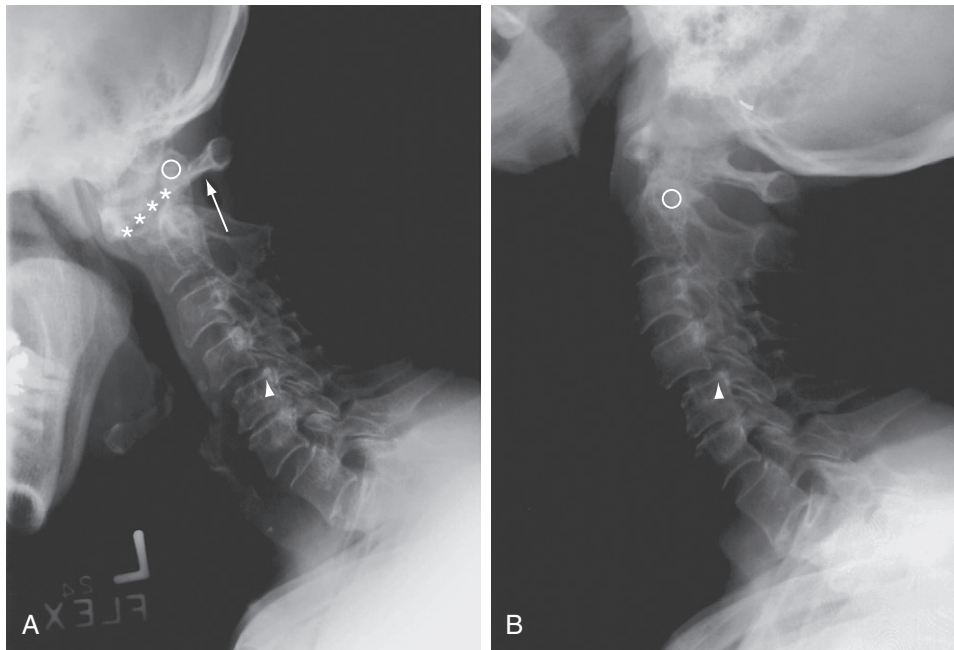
Rheumatoid arthritis of the cervical spine. A, Lateral radiograph in flexion shows severe anterior atlantoaxial subluxation with a wide anterior atlantodental interval (asterisks) and a decreased posterior atlantodental interval (arrow). B, Almost complete reduction of subluxation is noted on the lateral view in extension. Subaxial subluxation is evident at the level of C4-C5 (arrowheads) with erosive changes in various facet joints. O, odontoid. (Courtesy Dr. Barbara Weissman.)
